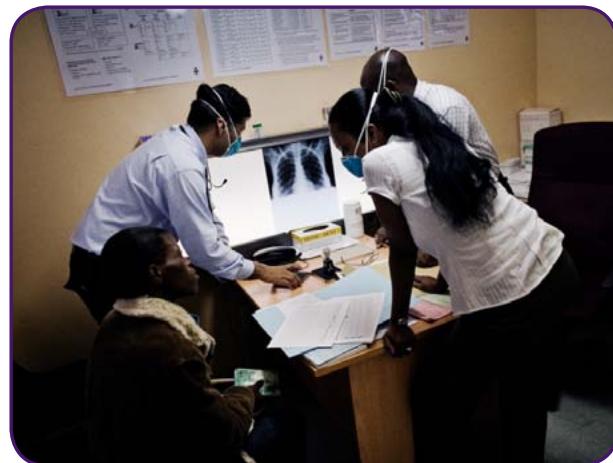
A PIH researcher looks at a chest x-ray at an outpatient clinic in Lesotho
